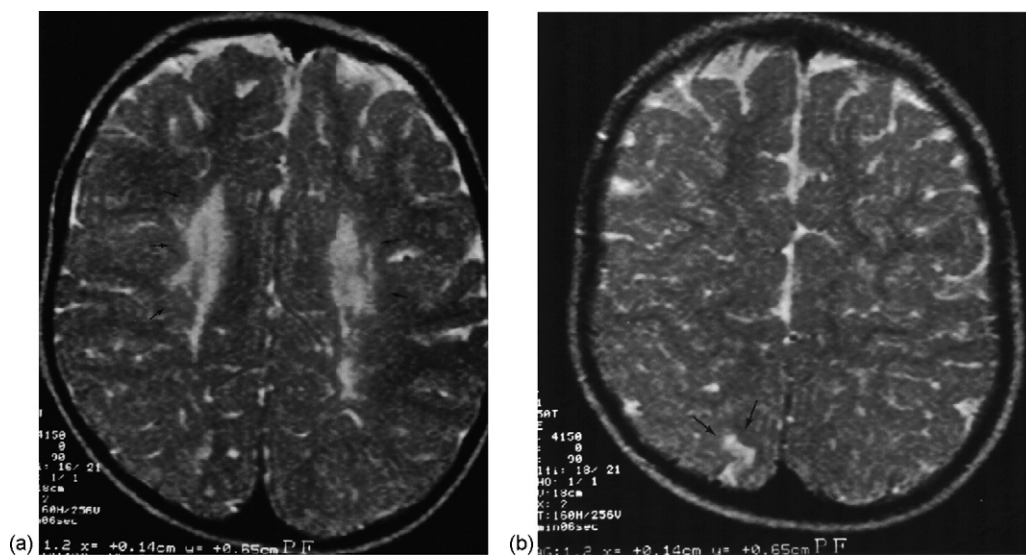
(a) T2-weighted MRI shows periventricular leukomalacia (arrows). (b) T2-weighted MRI shows ulegyria (arrows).
